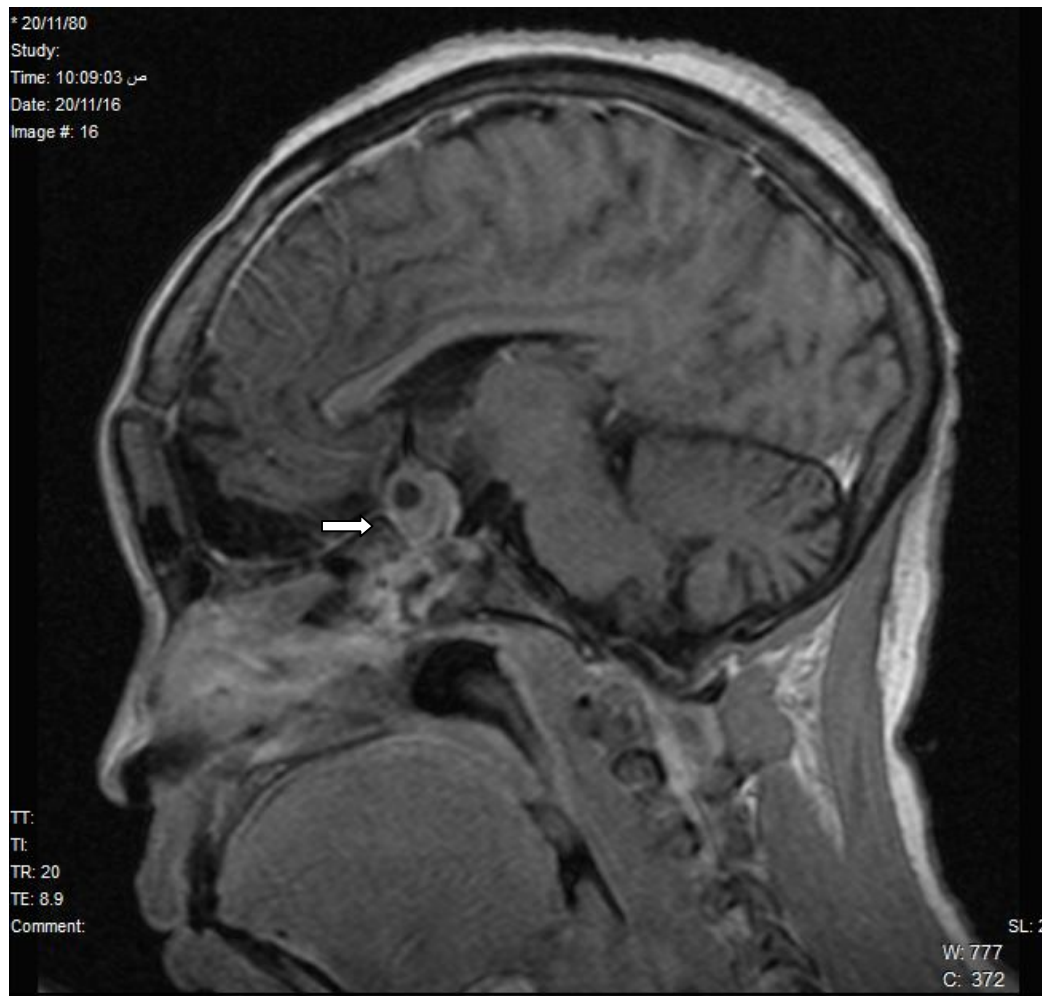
MRI Brain sagittal T1 WI with contrast showing macroadenoma for 44 years old female
